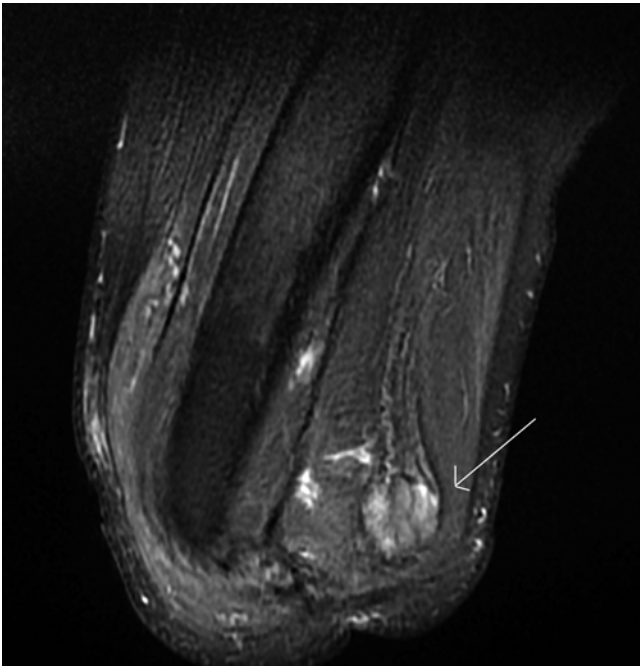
MRI image of a large sciatic nerve neuroma after a leg amputation – white arrow (Image courtesy of Andrea Trescot, MD)
